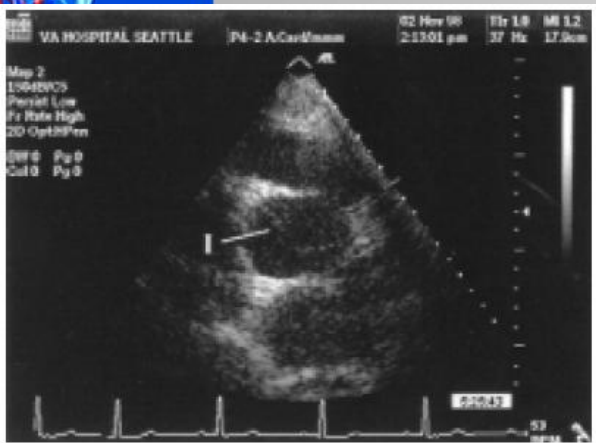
Parasternal short-axis view above the aortic valve. There is a linear echodensity that suggests an intimal flap (*I*).
